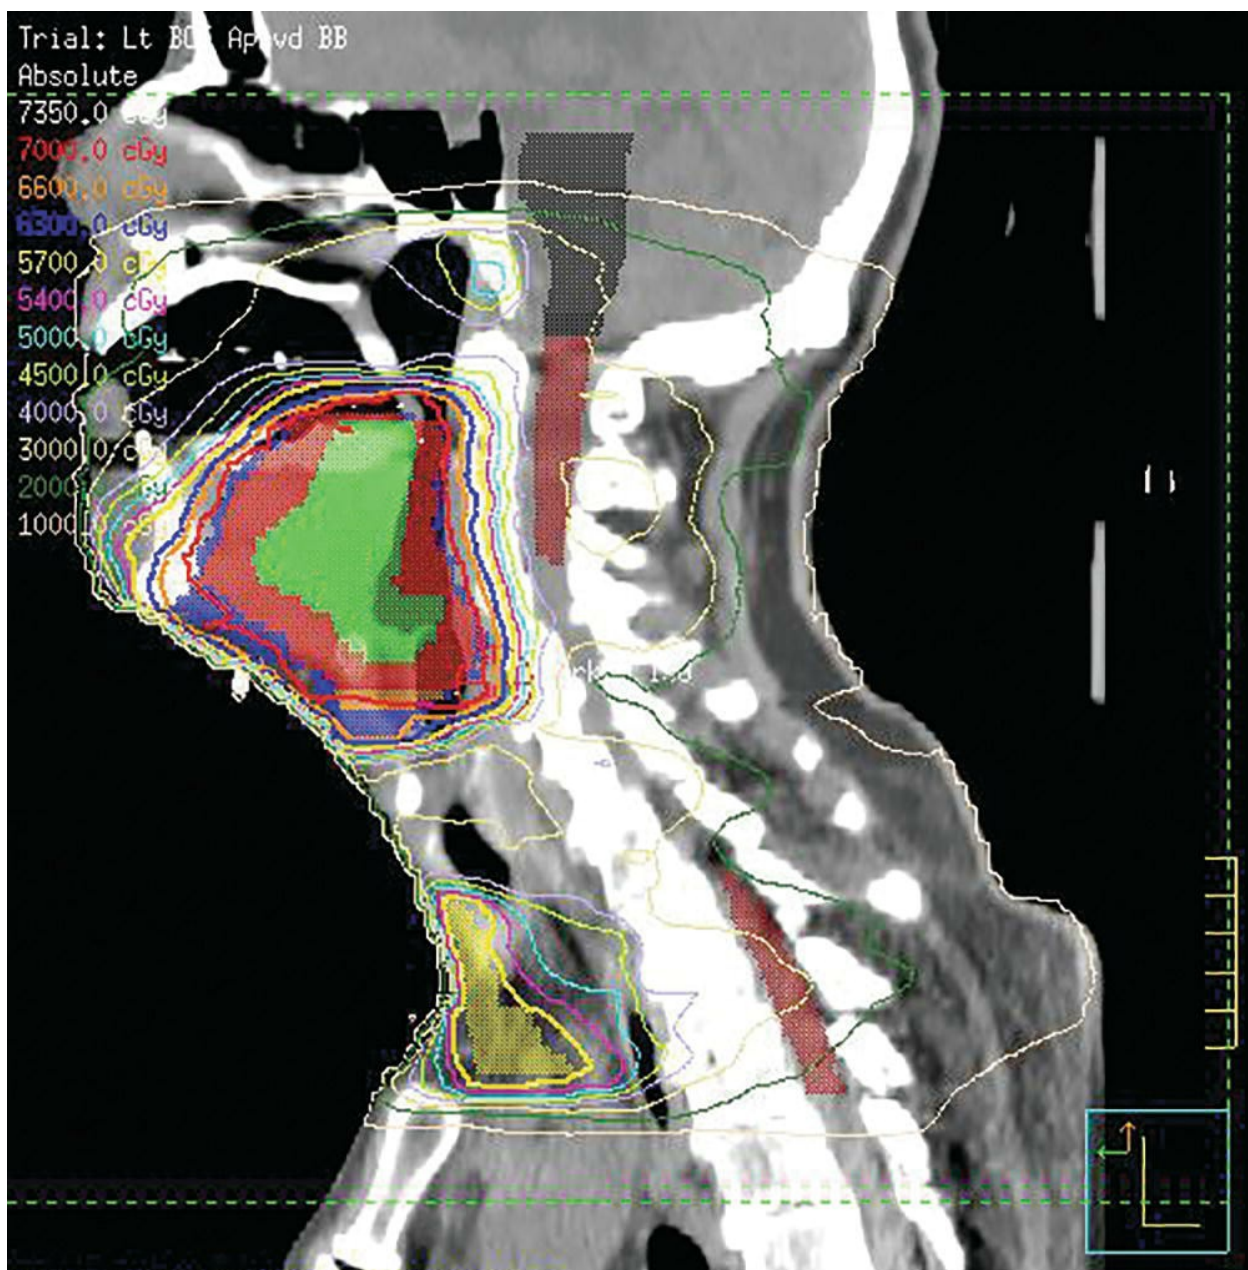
A: A CT scan is used for dosimetry purposes in the radiation
